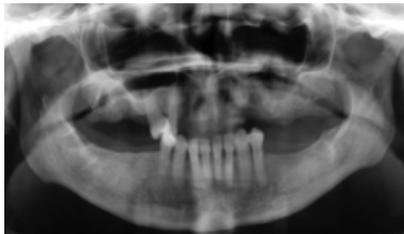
Postoperative panoramic radiograph after removal of decayed teeth and revision of the left maxillary sinus.
